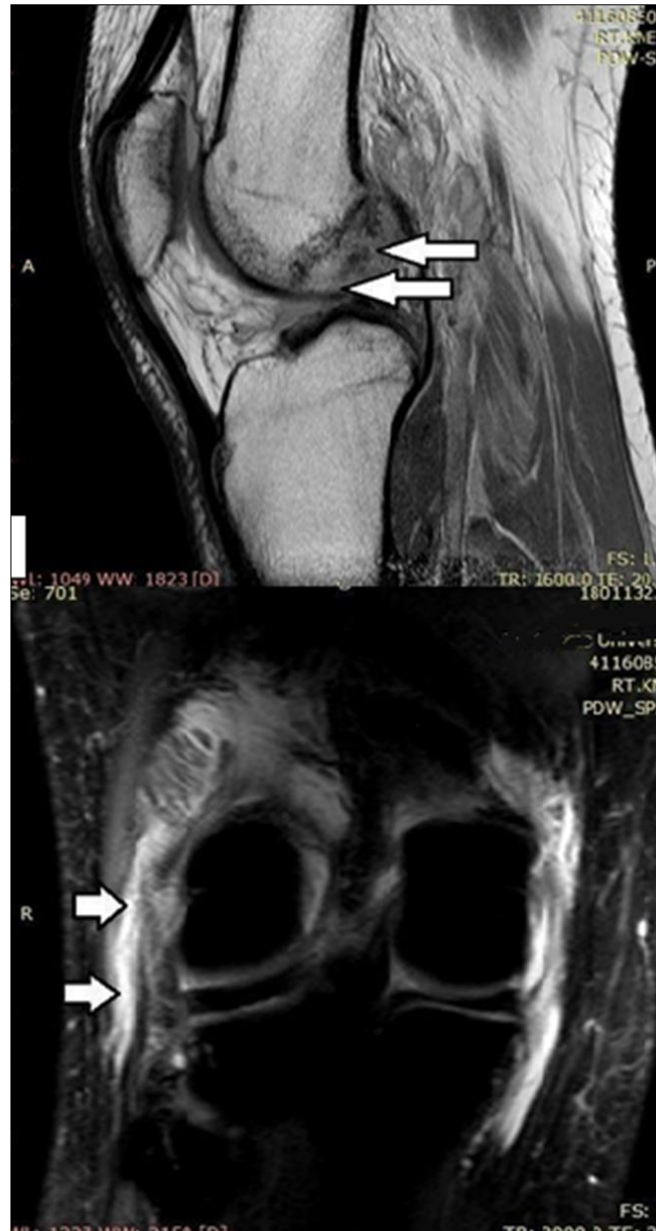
(A): Sagittal PDW knee MR image demonstrating complete tear of Anterior cruciate ligament fibers with no surrounding soft tissue edema suggesting chronic tear (arrows). (B): Sagittal PDW (SPAIR) knee MR image, lateral Collateral Ligament shows faint bright signal suggesting its sprain (arrows).
